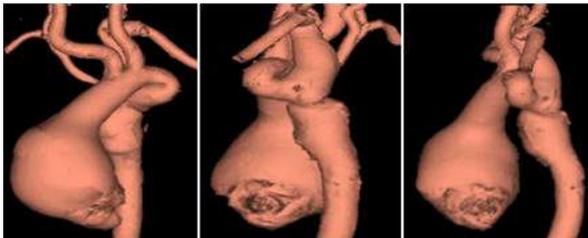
(A-C) CT aortic angiography, 3-D volume rendered images show proximal ascending aortic fusiform aneurysm with corctation of descending thoracic aorta.
